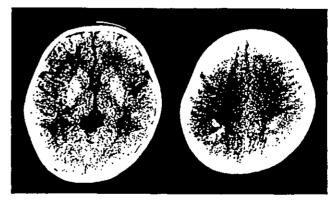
Brain computed tomogram of patient 3 showing multiple calcifications in the bilateral basal ganglia (*left*) and subcortical white matter in the occipital lobes (*right*).
